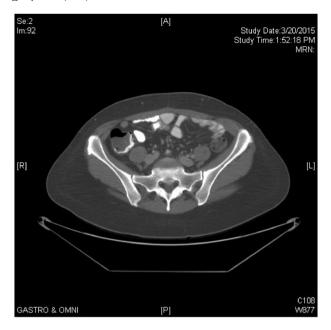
Postoperative computed tomography scan at 30 months postoperatively.
